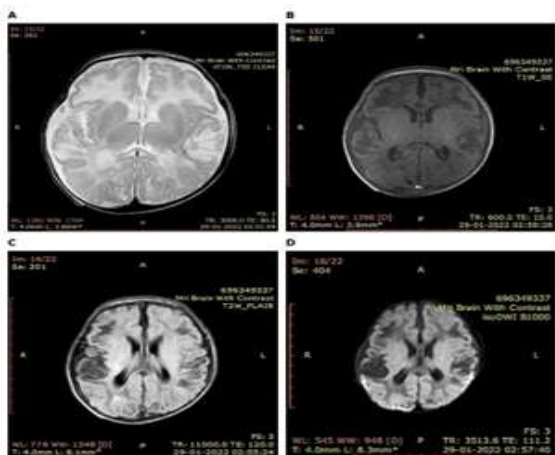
MRI findings of hypoxic-ischemic encephalopathy.
